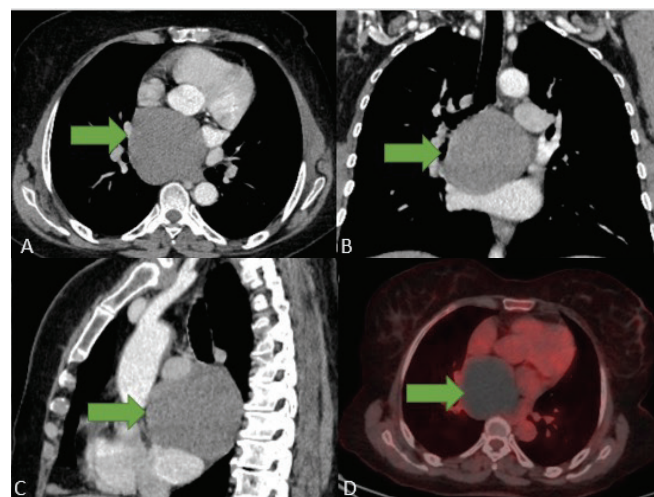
The cyst on CT and PET-CT images. Axial mediastinum window (a), sagittal mediastinum window (b), coronal mediastinum window (c), PET-CT fusion on axial image (d) (green arrow shows cyst).
